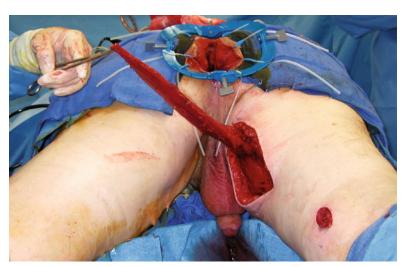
Prostatorectal fistula. (a) CT of pelvis. Note typical air in bladder and thick wall bladder base from chronic infections. (b) Hypaque enema noting bladder
